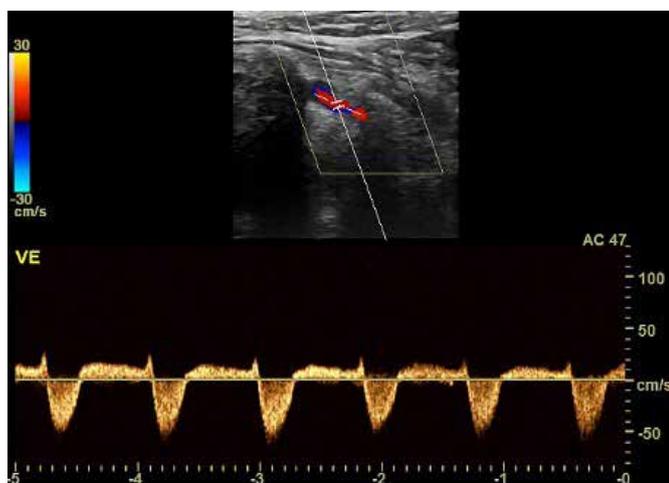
Spectral Doppler of the left vertebral artery showing a partially inverted blood flow pattern, with medium-systolic deceleration, transmitting an image similar to a rabbit ("bunny rabbit" sign).
